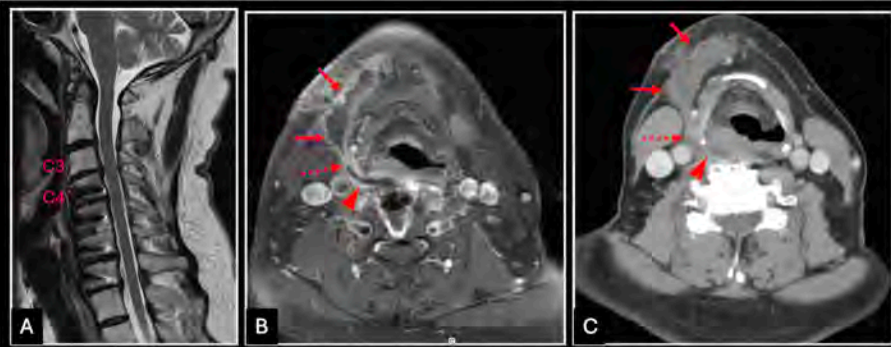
Sagittal T2WI (A) shows anterior cervical discectomy and fixation (ACDF) at C4-C7 with osseous fusion of C5 and C6 vertebral bodies. Moderate spinal canal stenosis at C3-C4 with associated neural foraminal narrowing consistent with adjacent segment disease. Axial T1WI post contrast neck (B) and axial CT soft tissue neck with contrast (C) show new ACDF changes at C3-C4 in the same patient with complication of prevertebral/retropharyngeal abscess formation (arrowheads) with fistulous tract tracking anteriorly into the submandibular region (dashed arrows) and anterior superficial neck phlegmonous changes (arrows). Effacement of the supraglottic larynx is noted.
